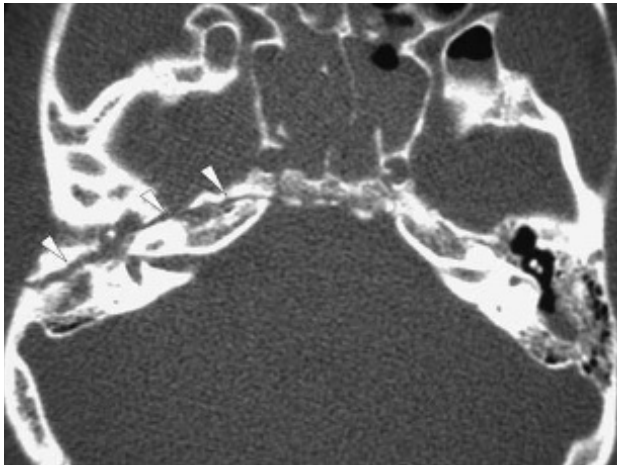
Typical CT appearance of a longitudinal fracture of the temporal bone. The fracture line (arrowed) passes anterior to the genu of the facial nerve.
